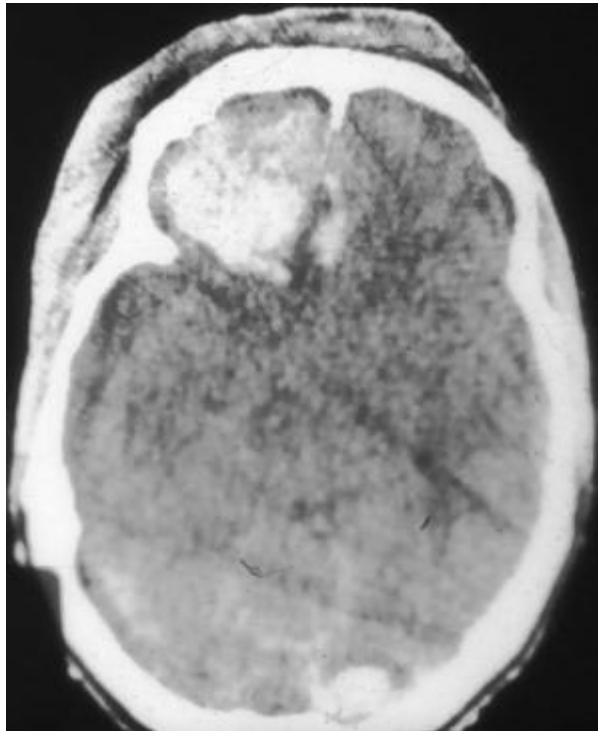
CT appearance of intracerebral haematoma
